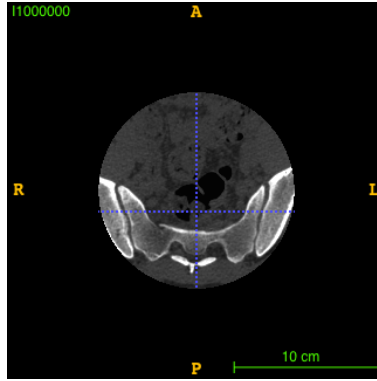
CT scan in which part of the hips are left out
